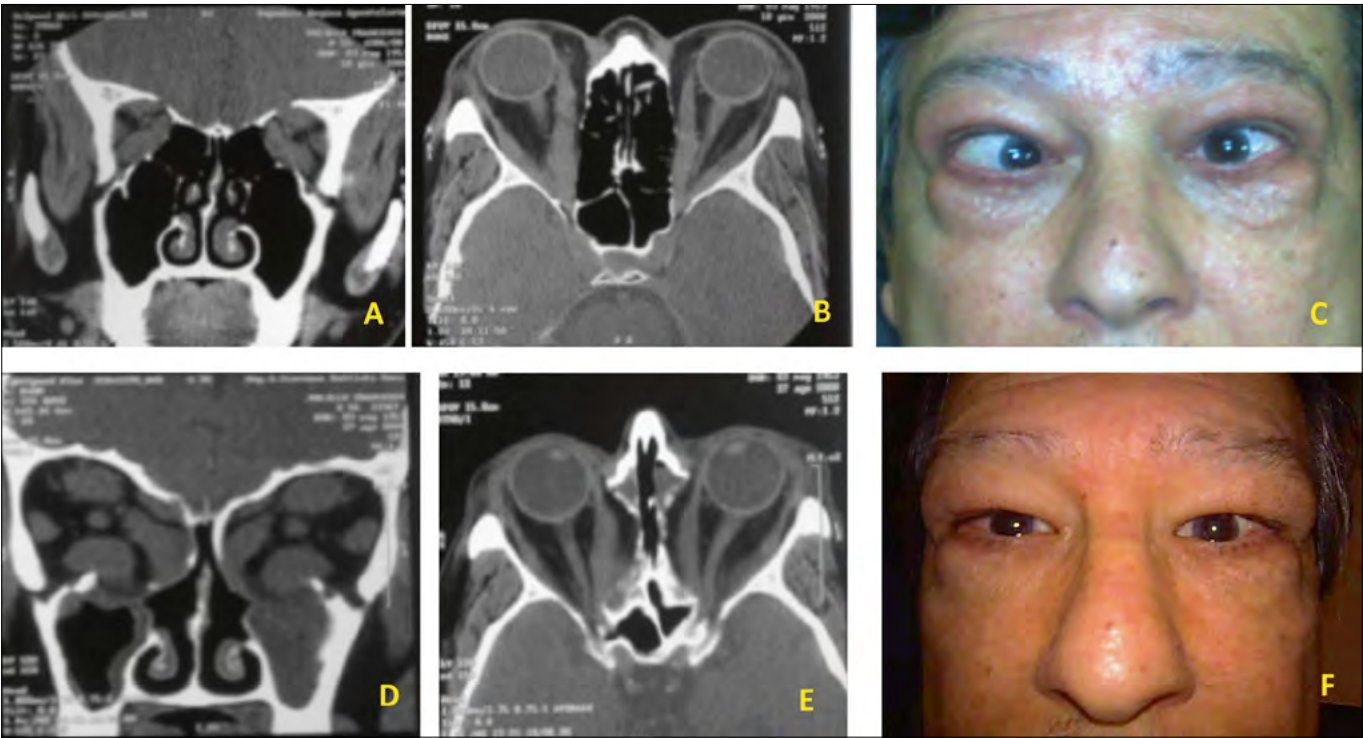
65-years old, male patient affected by severe TED with proptosis and strabismus. (A-C) Pre-operative CT-scan images and appearance. (D-F) CT-scan images and appearance after bilateral endoscopic orbital decompression.
